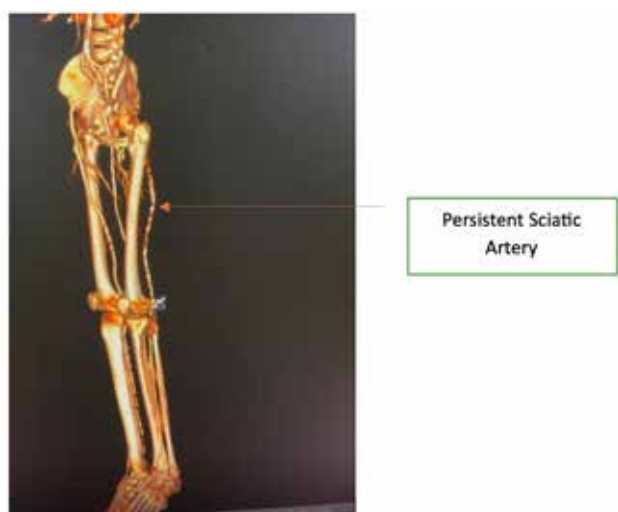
CT angiogram was performed, which showed PSA with subacute thrombotic occlusion
